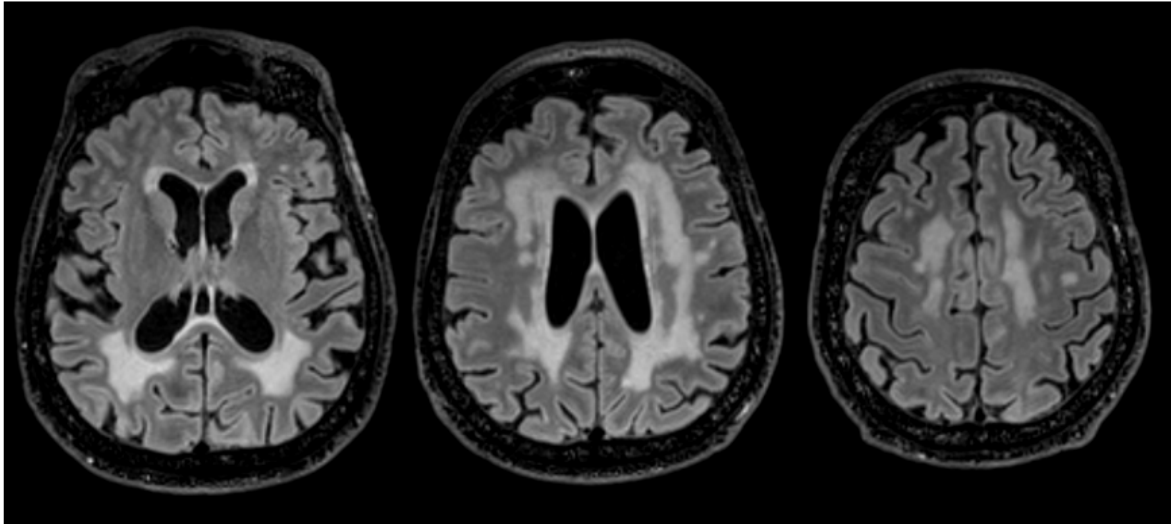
White matter hyper-intensities (T<sub>2</sub>w 3D FLAIR) (DM1, E2 genetic class, M/57 years old) (IRCCS Istituto delle Scienze Neurologiche di Bologna, Functional and Molecular Neuroimaging Unit, Ospedale Bellaria, Bologna)
